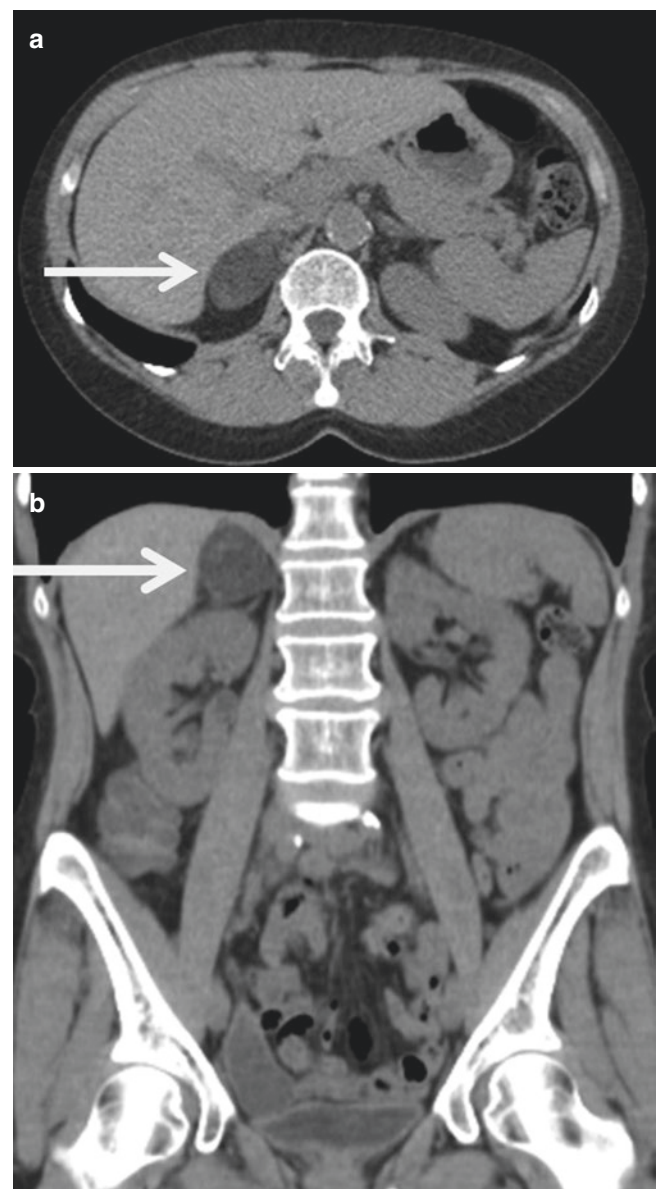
Computed tomography (CT) scan, right adrenal tumor (a - transverse view, b - anterior view). Right adrenal lesion measuring 4.1×2.7 cm with low-attenuation, 20 Hounsfield units (arrow)
